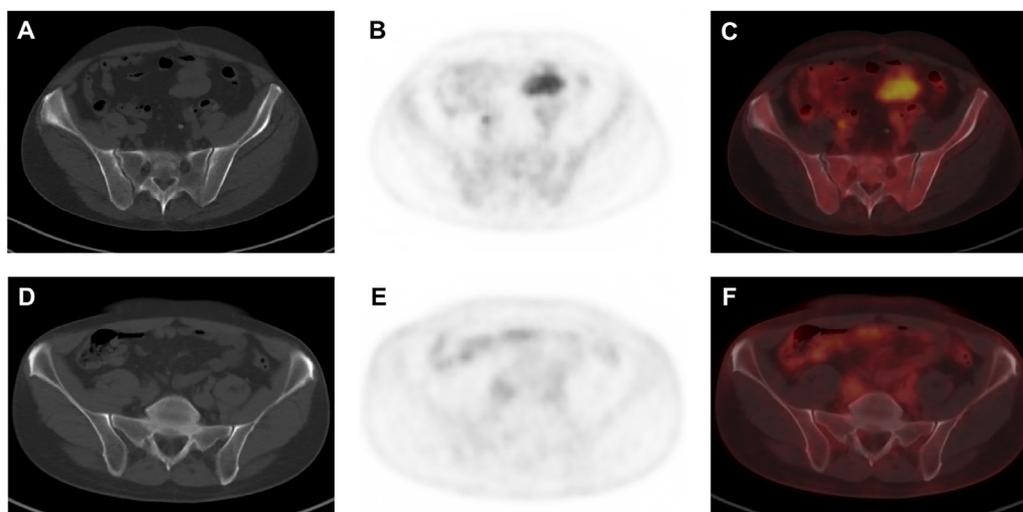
(A) Axial, attenuation-correction CT, (B) axial ^{18}F -DCFPyL PET, and (C) axial ^{18}F -DCFPyL PET/CT images through the pelvis from a 71-year-old man with chronic anemia and activated bone marrow that shows diffuse, mildly increased radiotracer uptake. (A) Axial, attenuation-correction CT, (B) axial ^{18}F -DCFPyL PET, and (C) axial ^{18}F -DCFPyL PET/CT images from the pelvis of a 59-year-old man with normal hemoglobin level and without activated bone marrow. No significant radiotracer uptake is visualized within the bone marrow.
